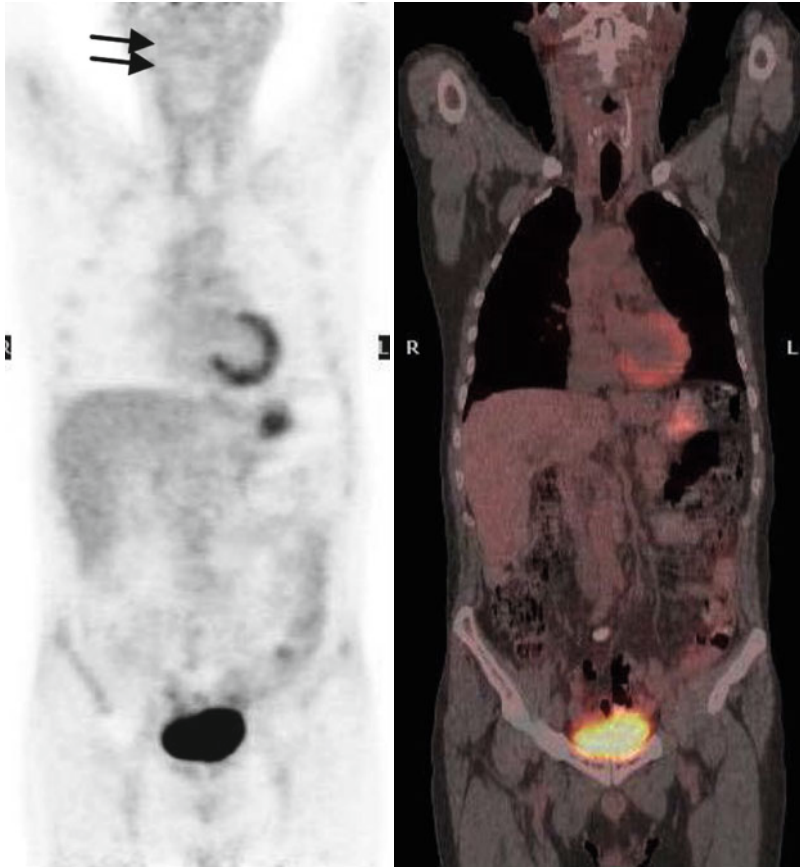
Posttreatment PET/CT after ESHAP chemotherapy shows two small hypermetabolic lymph nodes in the right parotid and at the upper right cervical area (*arrows*)
